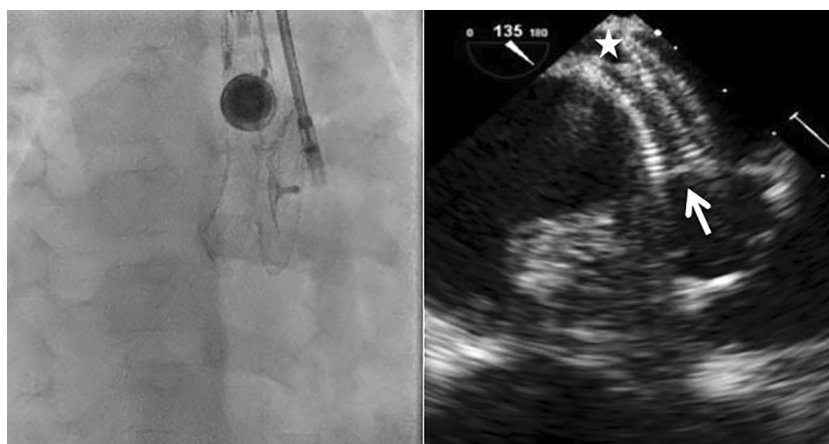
Transoesophageal echocardiogram confirmed large secundum atrial septal defect (white star) measured at 15 mm with deficient aortic rim
